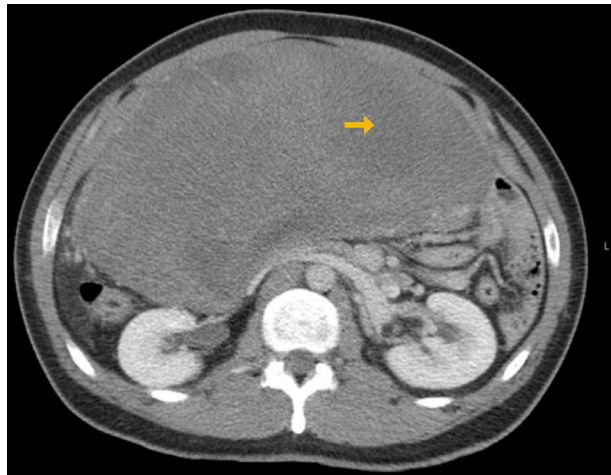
Massive intraabdominal fibromatosis in a 45-year-old male. Axial CT image demonstrating a large heterogeneously enhancing intraabdominal mass. Note the areas of less contrast enhancement due to increase collagen content and myxoid degeneration (arrow).
